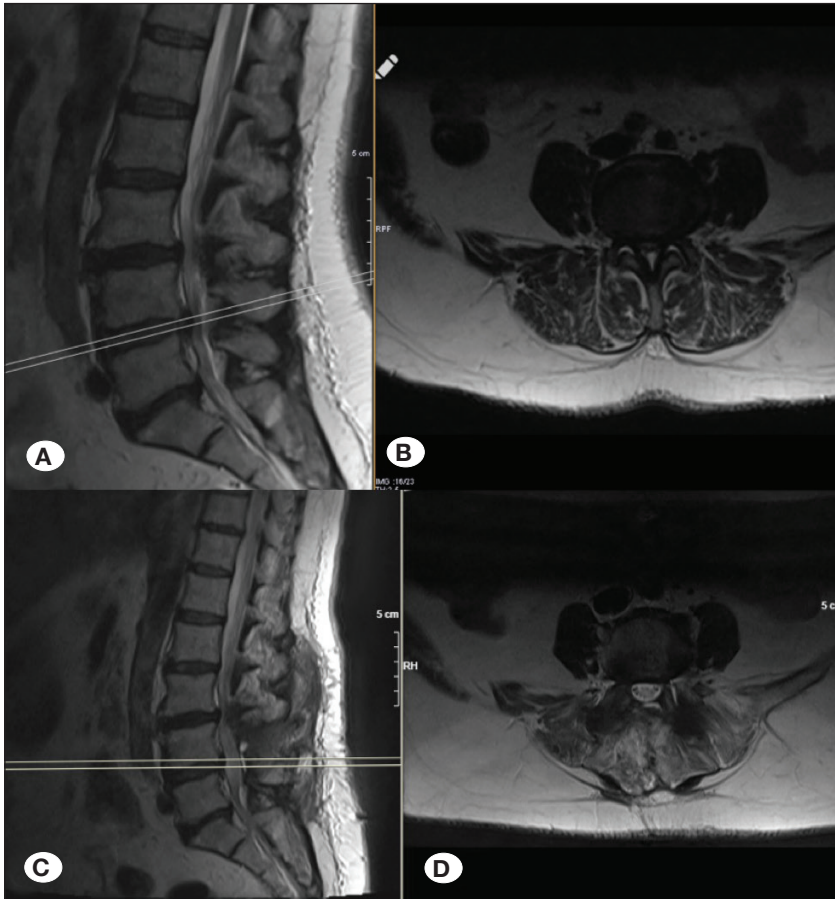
Preoperative (A,B) and postoperative (C,D) sagittal and axial MR images of a case with L4-5 lumbar spinal stenosis who underwent L4 total laminectomy with L4-L5 pedicle screw instrumentation.
